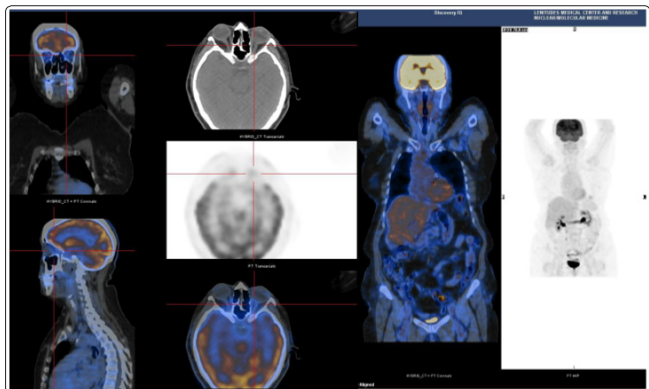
PET-CT-scan, with absence of suspect hypermetabolic foci, March 2019
